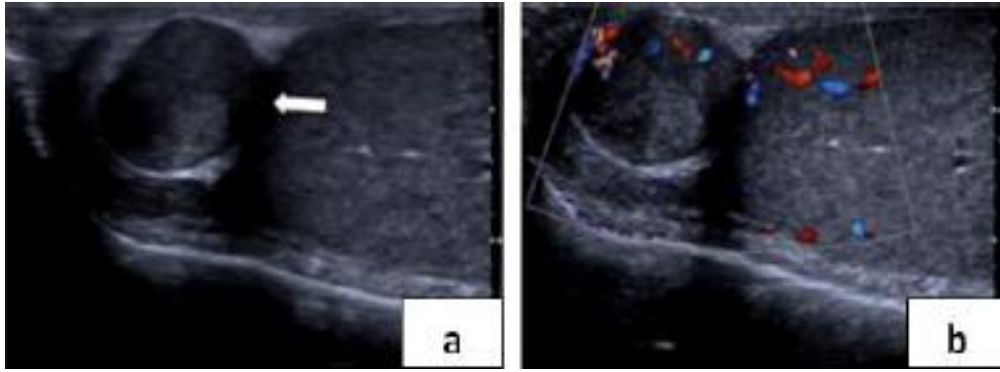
shows the extra testicular adenomatoid lesion. (a) A heterogeneous lesion (arrow) measuring 12mm is noted within the right epididymal head. (b) Color Doppler signal is demonstrated within the lesion (Dogra et al, 2001).
